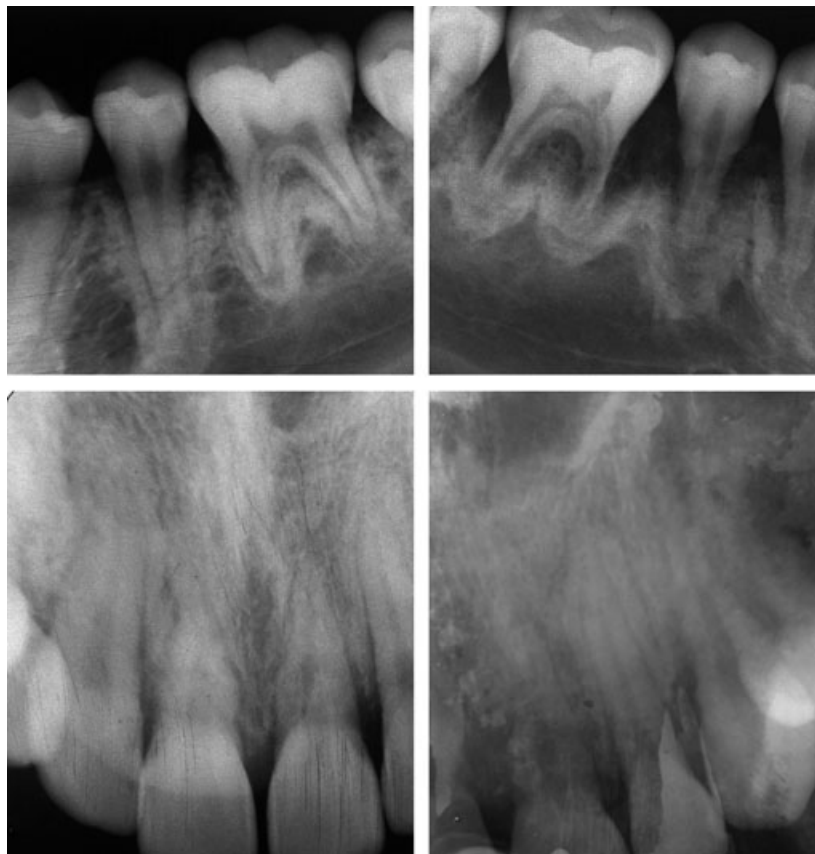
Periapical radiographs demonstrating close view of bone sclerosis in the incisal and premolar-molar areas.
